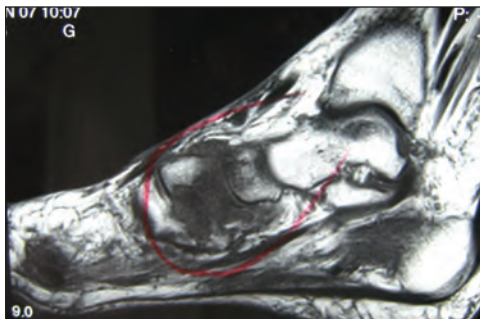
Case 1: MRI of foot confirming acute neuroarthropathy
